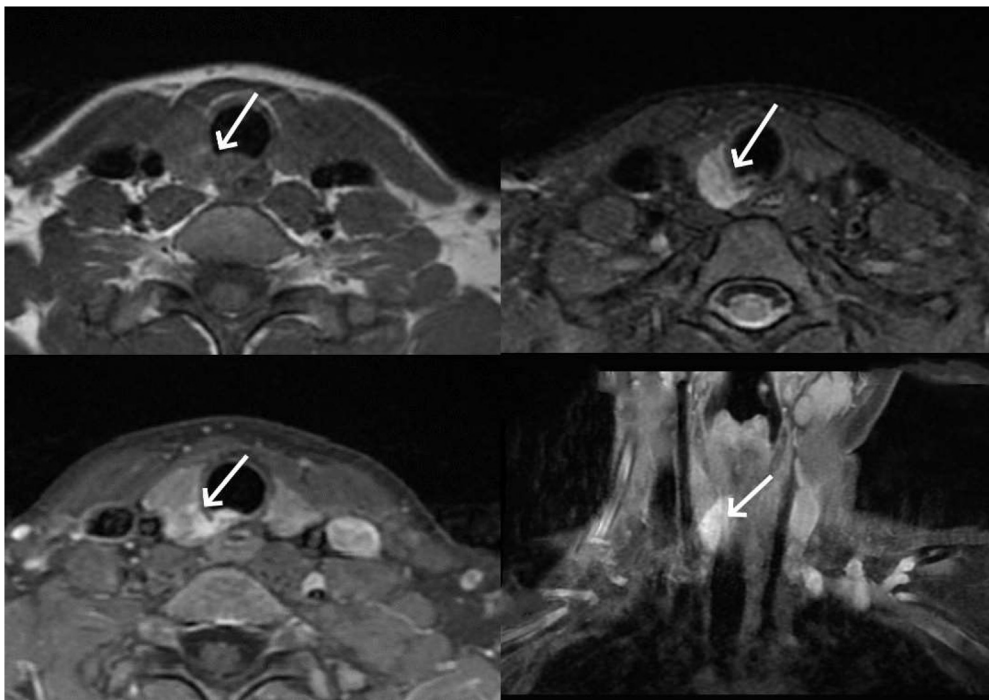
MRI images of the neck. (A) There was an irregular hypo-signal nodule (white arrow) in the right lobe of thyroid on T1WI transverse imaging. (B) The nodule (white arrow) was hyper-signal on T2WI/FS image. (C) The nodule (white arrow) was enhanced on contrast-enhanced T1WI transverse imaging and invaded the membranous part of the trachea.
